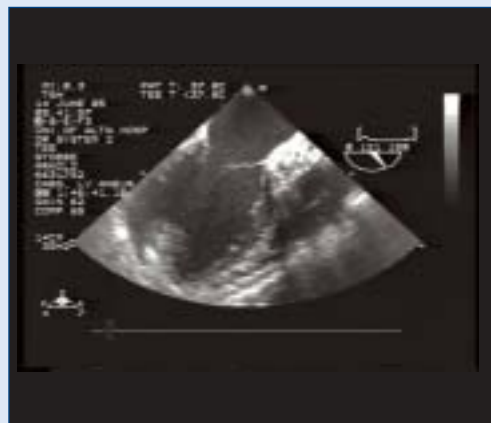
Salvatore's transesophageal echocardiogram.
